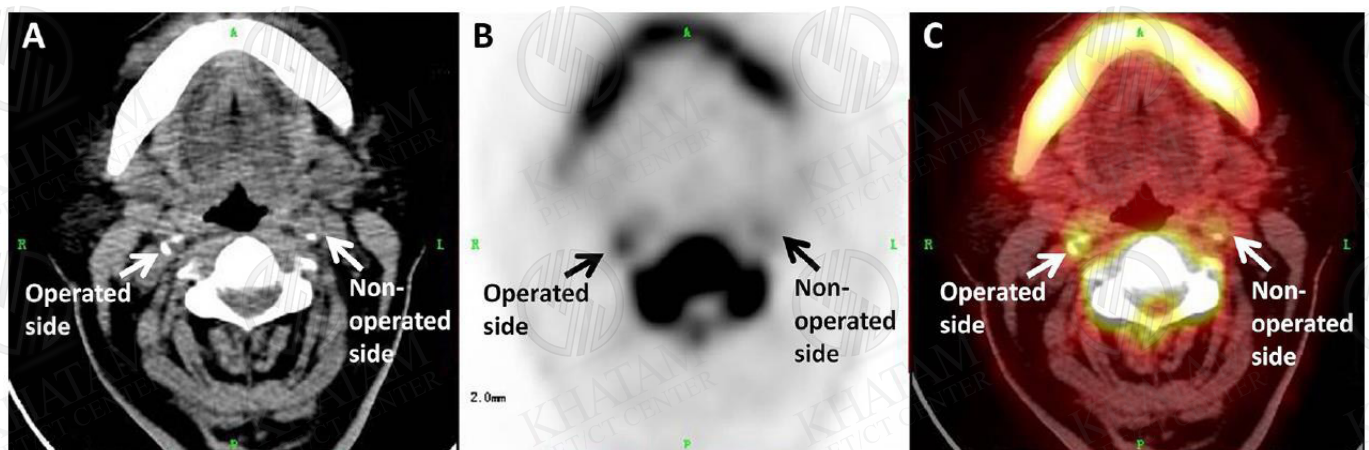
Transaxial ^{18}F -NaF PET-CT imaging of a patient whose right carotid artery was the operated side: (A) CT; (B) PET; (C) merged PET-CT images. CTA of the cerebral vessels confirmed that the stenosis rate of the right carotid artery was 90% and that of the left carotid artery was 30%. ^{18}F -NaF accumulated in the bilateral carotid artery plaques.
